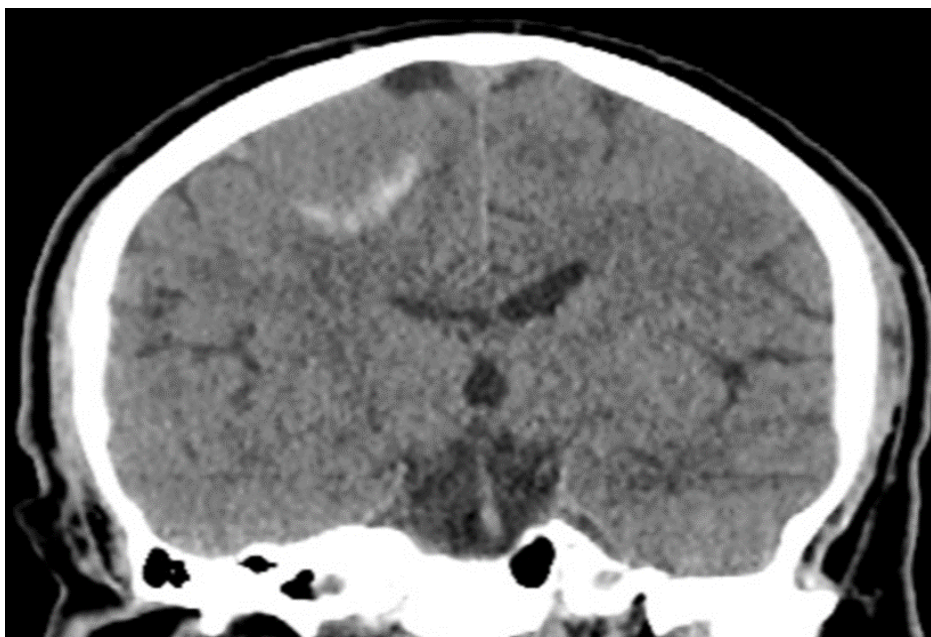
Coronal CT image of a patient with atypical meningioma
